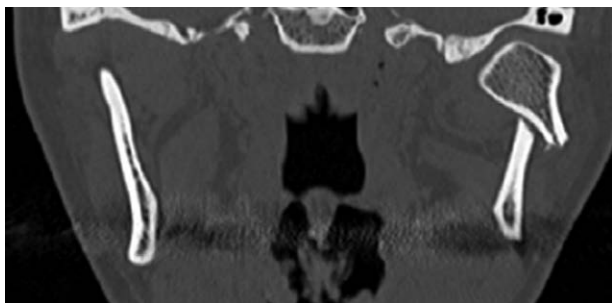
Coronal computed tomography findings in the left mandibular condylar base fracture with lateral displacement.
